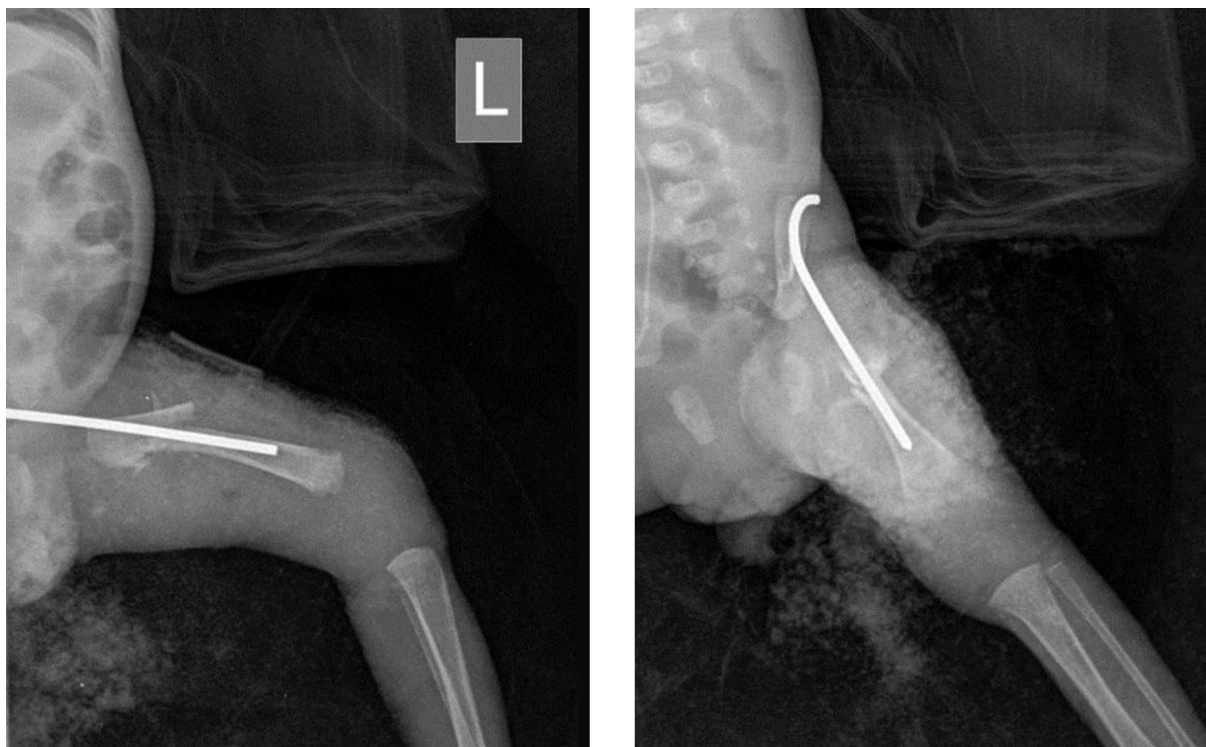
Radiograph After Insertion of INTRAMEDULLARY KIRSCHNER WIRE
